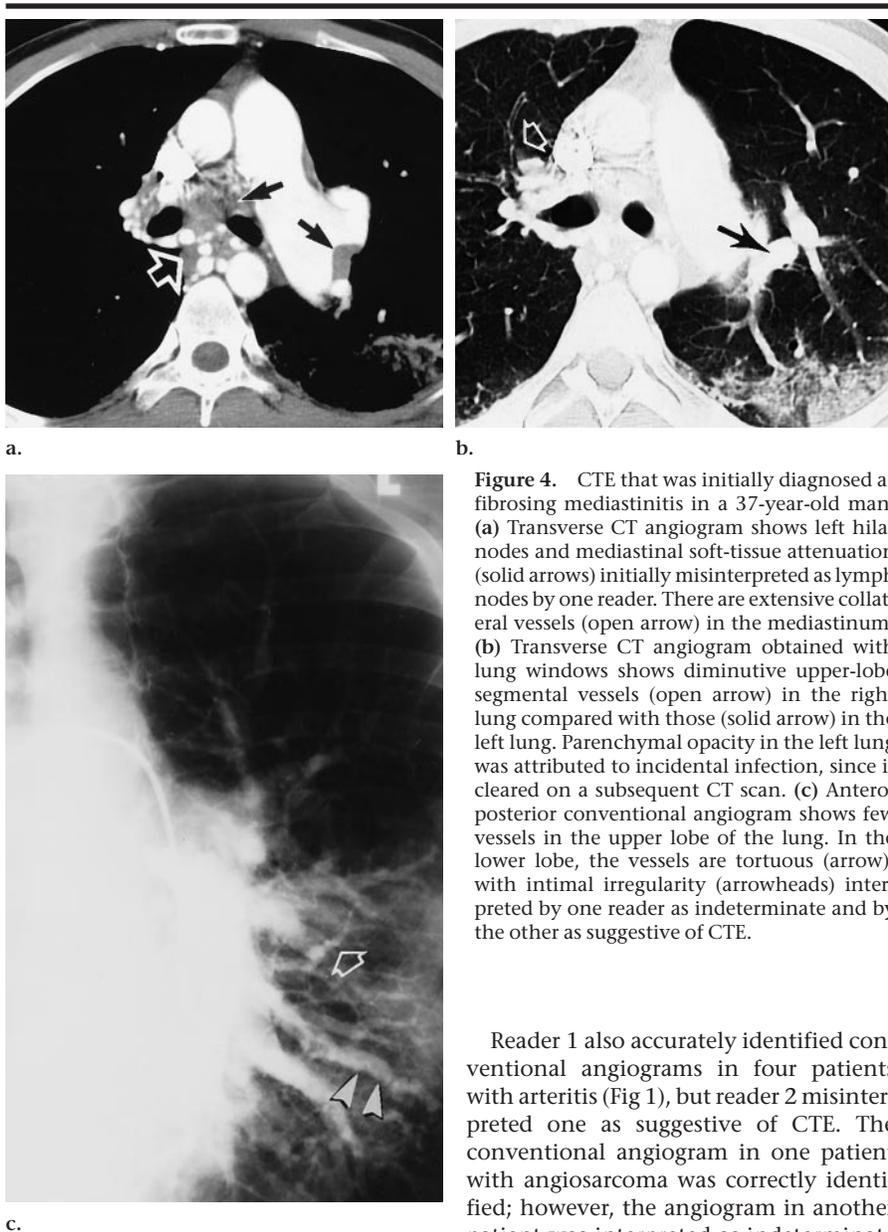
CTE that was initially diagnosed as fibrosing mediastinitis in a 37-year-old man. (a) Transverse CT angiogram shows left hilar nodes and mediastinal soft-tissue attenuation (solid arrows) initially misinterpreted as lymph nodes by one reader. There are extensive collateral vessels (open arrow) in the mediastinum. (b) Transverse CT angiogram obtained with lung windows shows diminutive upper-lobe segmental vessels (open arrow) in the right lung compared with those (solid arrow) in the left lung. Parenchymal opacity in the left lung was attributed to incidental infection, since it cleared on a subsequent CT scan. (c) Anteroposterior conventional angiogram shows few vessels in the upper lobe of the lung. In the lower lobe, the vessels are tortuous (arrow), with intimal irregularity (arrowheads) interpreted by one reader as indeterminate and by the other as suggestive of CTE.
